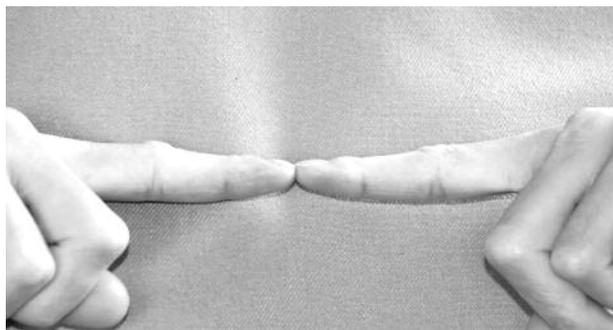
Lateral radiographs of both fingertips are taken in this position.
